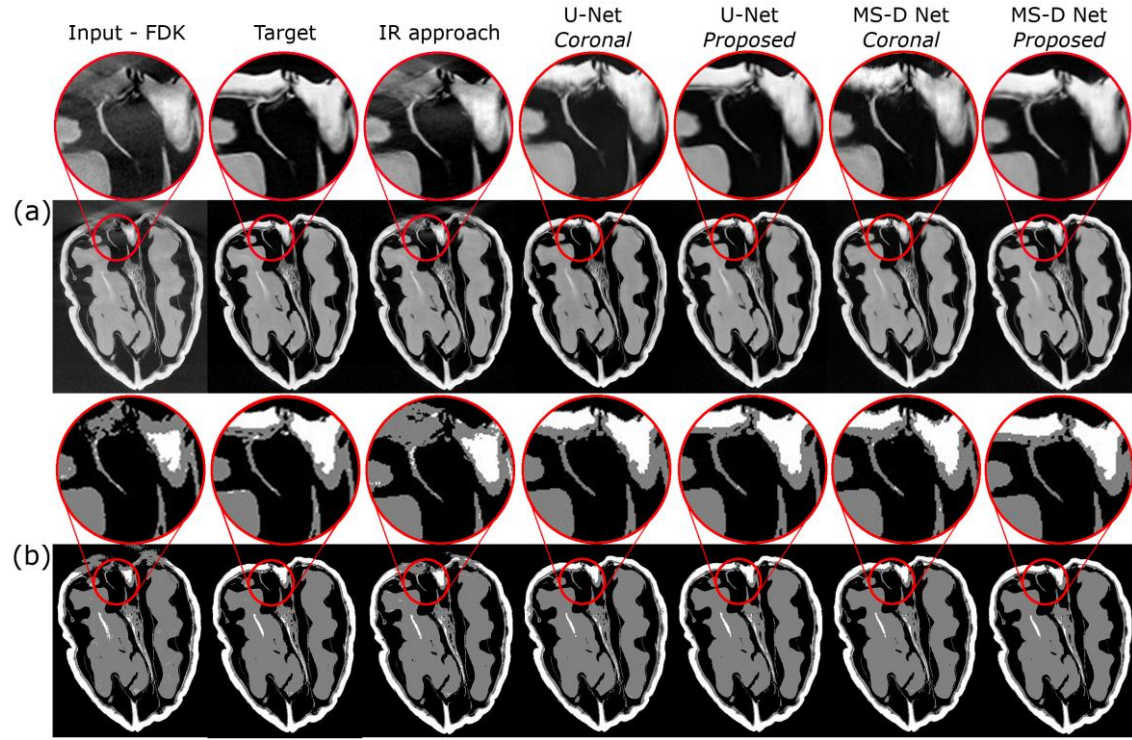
Example of a vertical slice of a CBCT scan processed by the HCAA reduction methods. The upper row (a) shows the output of the different artifact reduction approaches, and the bottom row (b) shows the corresponding segmented slices. Of the three evaluated Cartesian slice approaches, only the results of the coronal slice-based approach are visualized since it performed best in terms of SSIMs, MSEs and DSCs.
